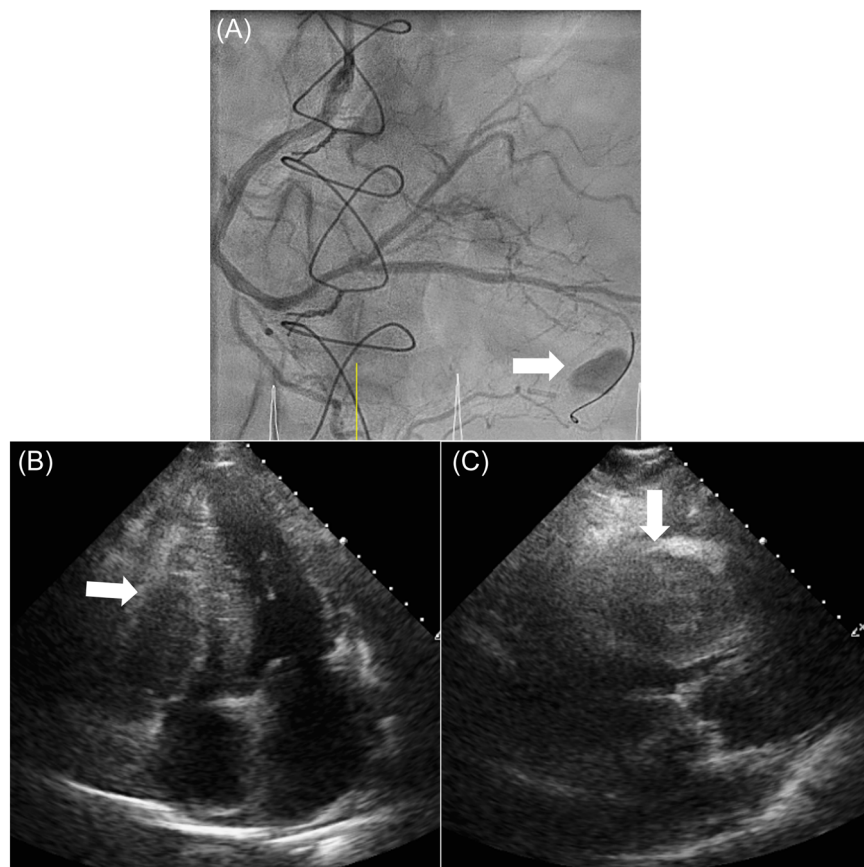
(A) Control angiogram post-PCI demonstrating contrast extravasation caused by wire perforation of the distal posterior descending artery. Apical (B) and parasternal long axis (C) echocardiographic views reveal a large right ventricular wall hematoma. PCI, percutaneous coronary intervention.
